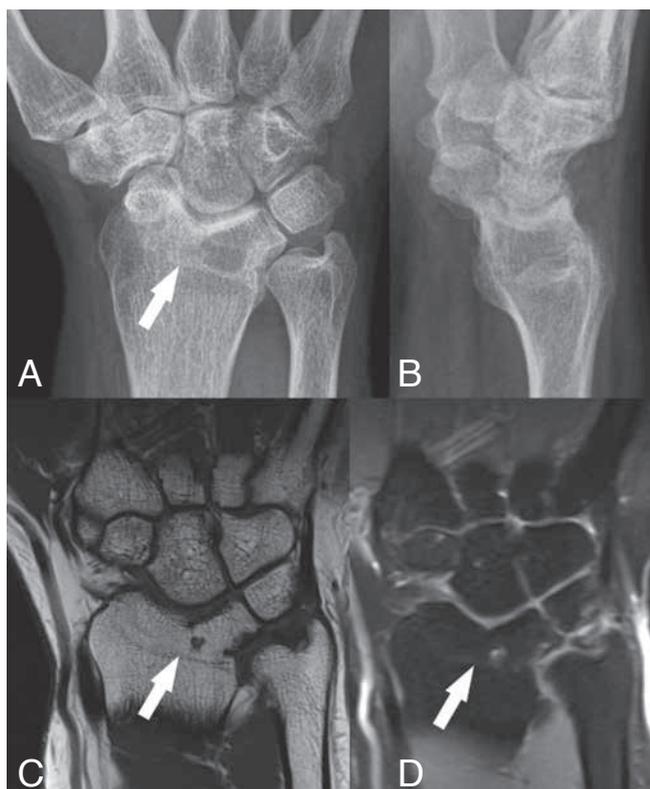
Secondary fusion due to arthritis. A and B: Plain radiography, C: Coronal SE T1-WI and D: Coronal SE T2-WI. There is a carpal “coalition” (here between the scaphoid and the lunate) but also an associated “coalition” with the radius (arrows). The scaphoid bone has lost a part of its volume and the proximal cortical delineation of the lunate bone is irregular. The fusion is secondary to a juvenile arthritis.
